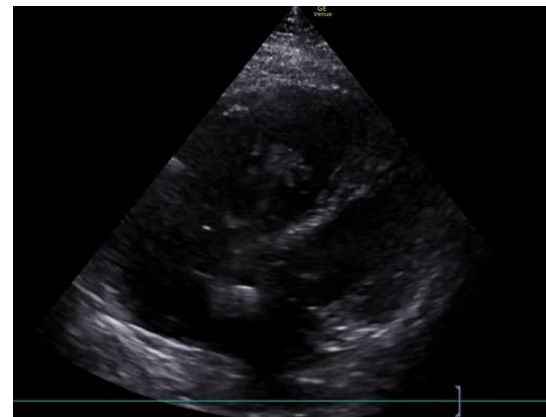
Apical 4-chamber (A4C) view of heart on POCUS showing RV:LV ratio greater than 1, RV
